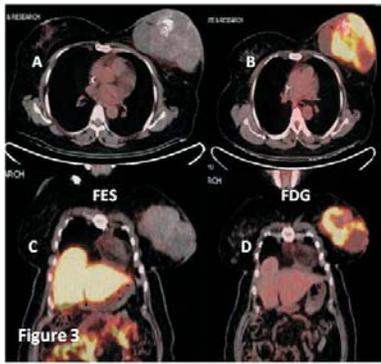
Left breast carcinoma with ER negative on IHC. FES Co-registered PET-CT: image A & C. Axial and Coronal view revealed no FES uptake in primary breast mass (True negative). FDG Co-registered PET-CT: image B & D. Axial and Coronal view revealed hypermetabolic left breast mass with necrosis.
